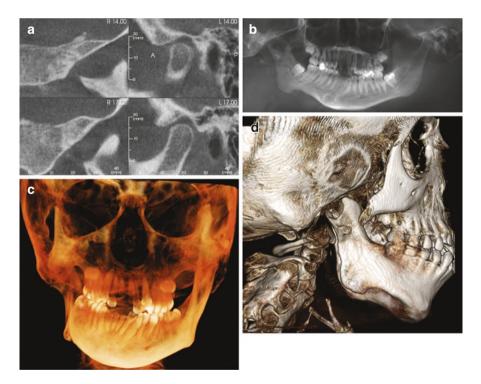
CBCT reformations show some of the features of hemifacial microsomia. The right affected side shows a lack of TMJ development (a) and a poorly developed mandible, resulting in asymmetry (b–d). The zygomatic arch is absent (d) (Courtesy, F. Eraso, DDS)
